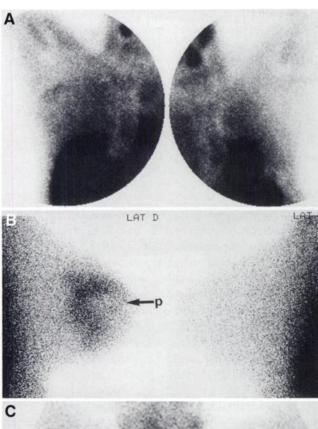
Planar images of patient 1 with MIBI show focal uptake (arrows) in left axilla: left and right anterior view (A) and left and right lateral view (B). MIVE scintigrams taken 15 min (C) and 2 h (D) after injection show focal uptake in left axilla (arrows) and normal distribution in right breast and axilla (D).
